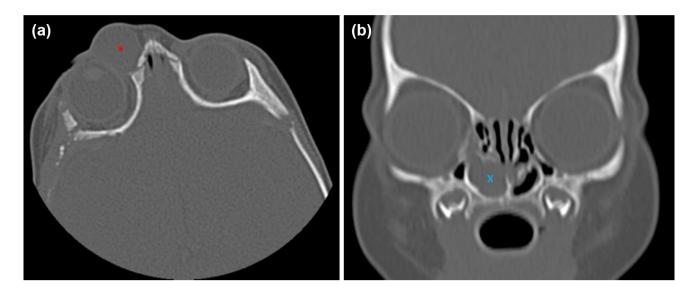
Congenital dacryocystocele with intranasal mucocele. a Axial CT showing a right-sided congenital dacryocystocele (red asterisk). b Coronal CT showing the intranasal mucocele (blue cross)
